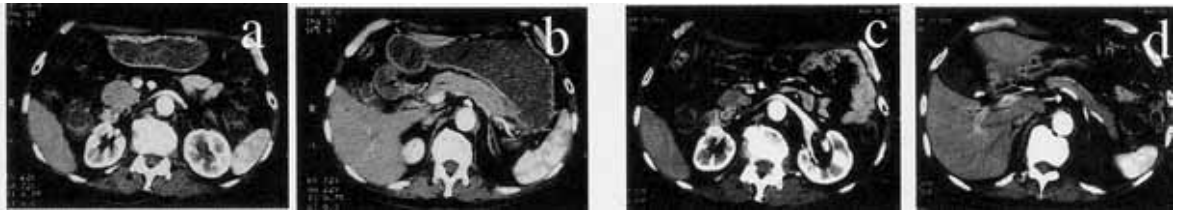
a,b: Pretreatment CT scans, showing diffuse enlargement of the pancreas. c,d: CT scans after starting steroid therapy, demonstrating remarkable improvement of enlargement of the pancreas.
